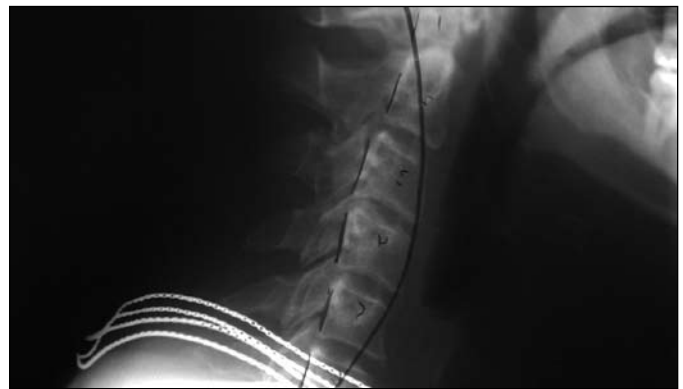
Lateral C-spine X-ray. The curved line shows the normal curve of the cervical spine. This X-ray demonstrates a straight cervical spine, indicative of a lot of muscle spasms which commonly occur with cervical radiculopathy.
